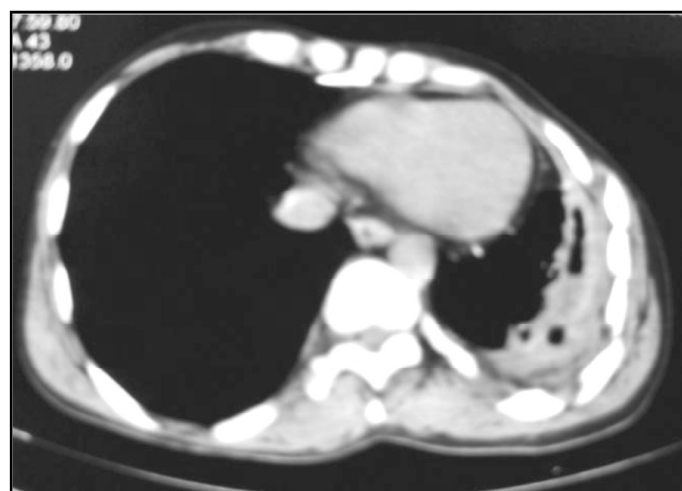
CT Scan of Thorax of Chronic Empyema Thoracis
